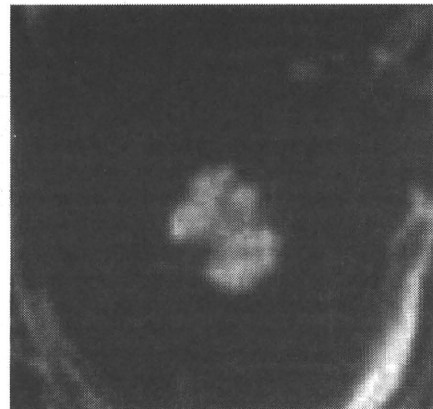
T2-weighted MR images for the tumor.
